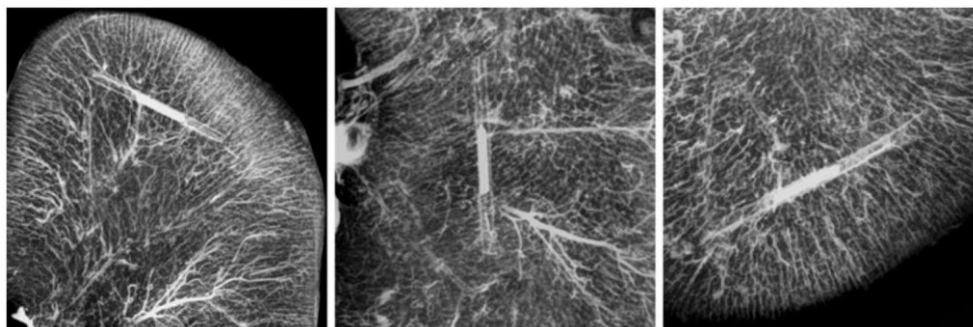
high-resolution X-ray imaging in low-kV exposure <sup>75</sup>
